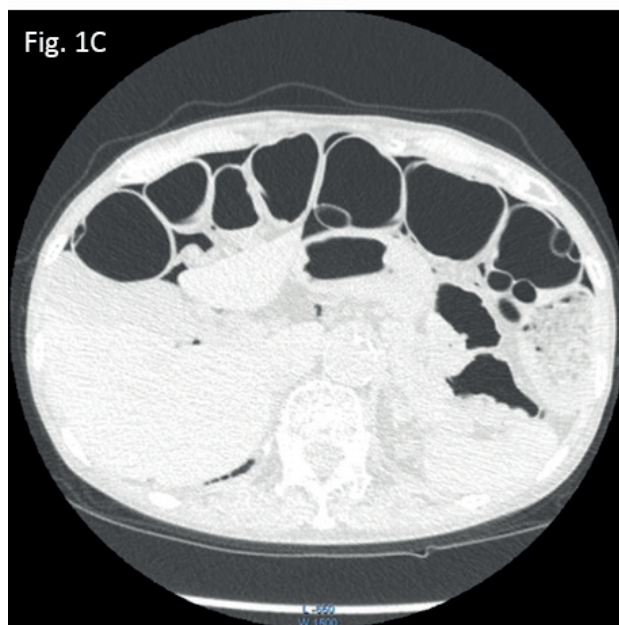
Abdominal CT scan reveals pneumoperitoneum and dilated intestinal canals, wherein the walls contain air-filled cysts.
